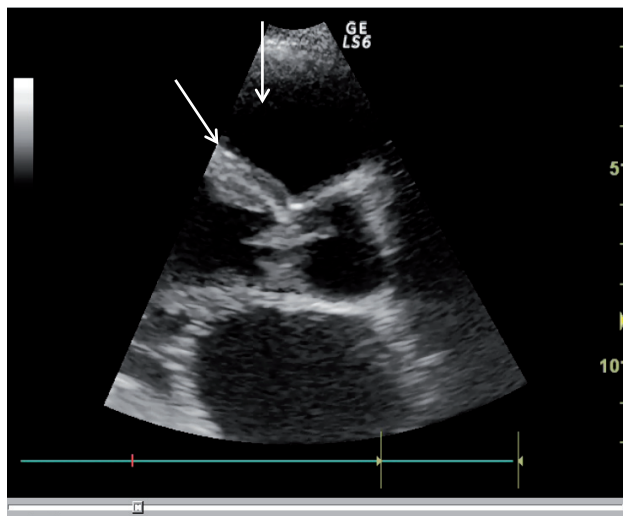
Transthoracic echocardiography image, zoom of left parasternal axis. The arrows show vegetation in the aortic and mitral valves.
